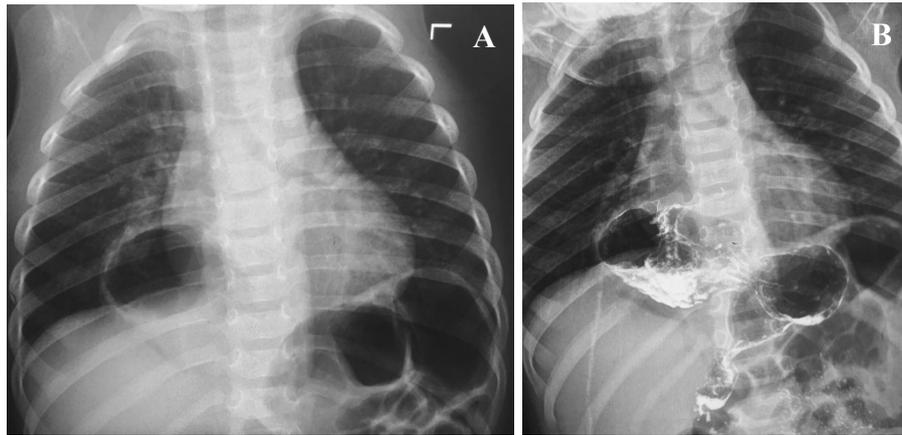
Simple chest X-ray (A) – right sided intrathoracic cavity mass. Chest X-ray with upper gastrointestinal contrasting (B) – “sandglass” appearance of the stomach
